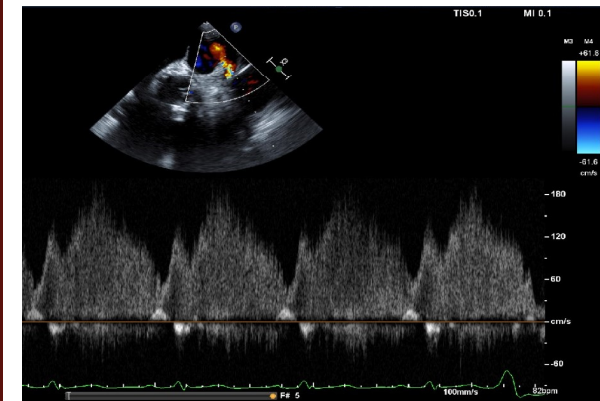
Color doppler of flow through the stenotic pulmonary vein showing increased velocity
